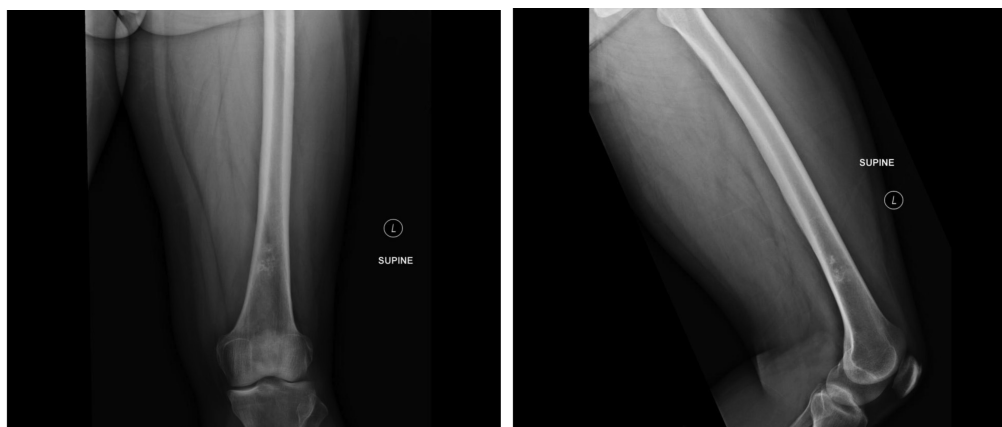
Left femur x-ray showed stippled calcifications within the distal femoral intramedullary cavity without additional aggressive features most consistent with an enchondroma. Given the information already provided by the high-resolution SPECT/CT BrightView examination, the x-ray or any additional radiologic evaluation would not be needed.
